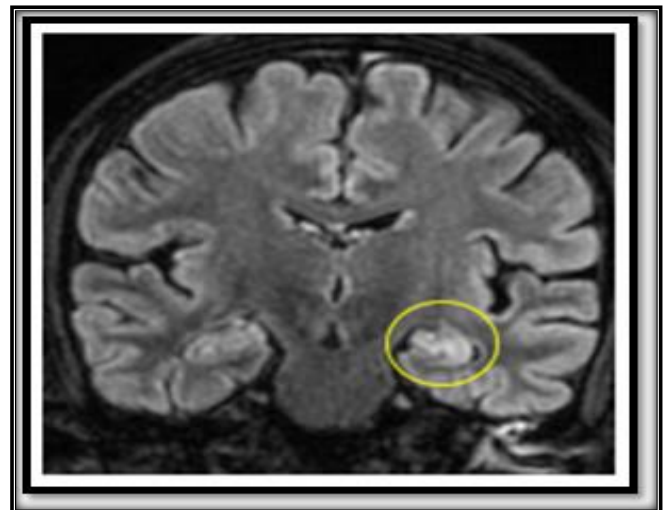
Coronal FLAIR image showing FLAIR hyperintensity without volume loss in the left hippocampus (yellow circle)
